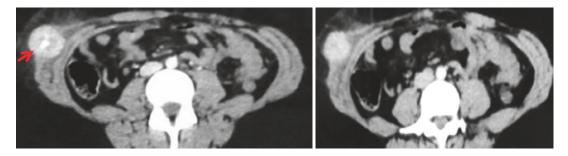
17-year-old woman with osteosarcoma. Contrast-enhanced abdominal CT scan shows enhancing lesion in right external and internal oblique muscles with multifocal calcifications (*arrows*)
